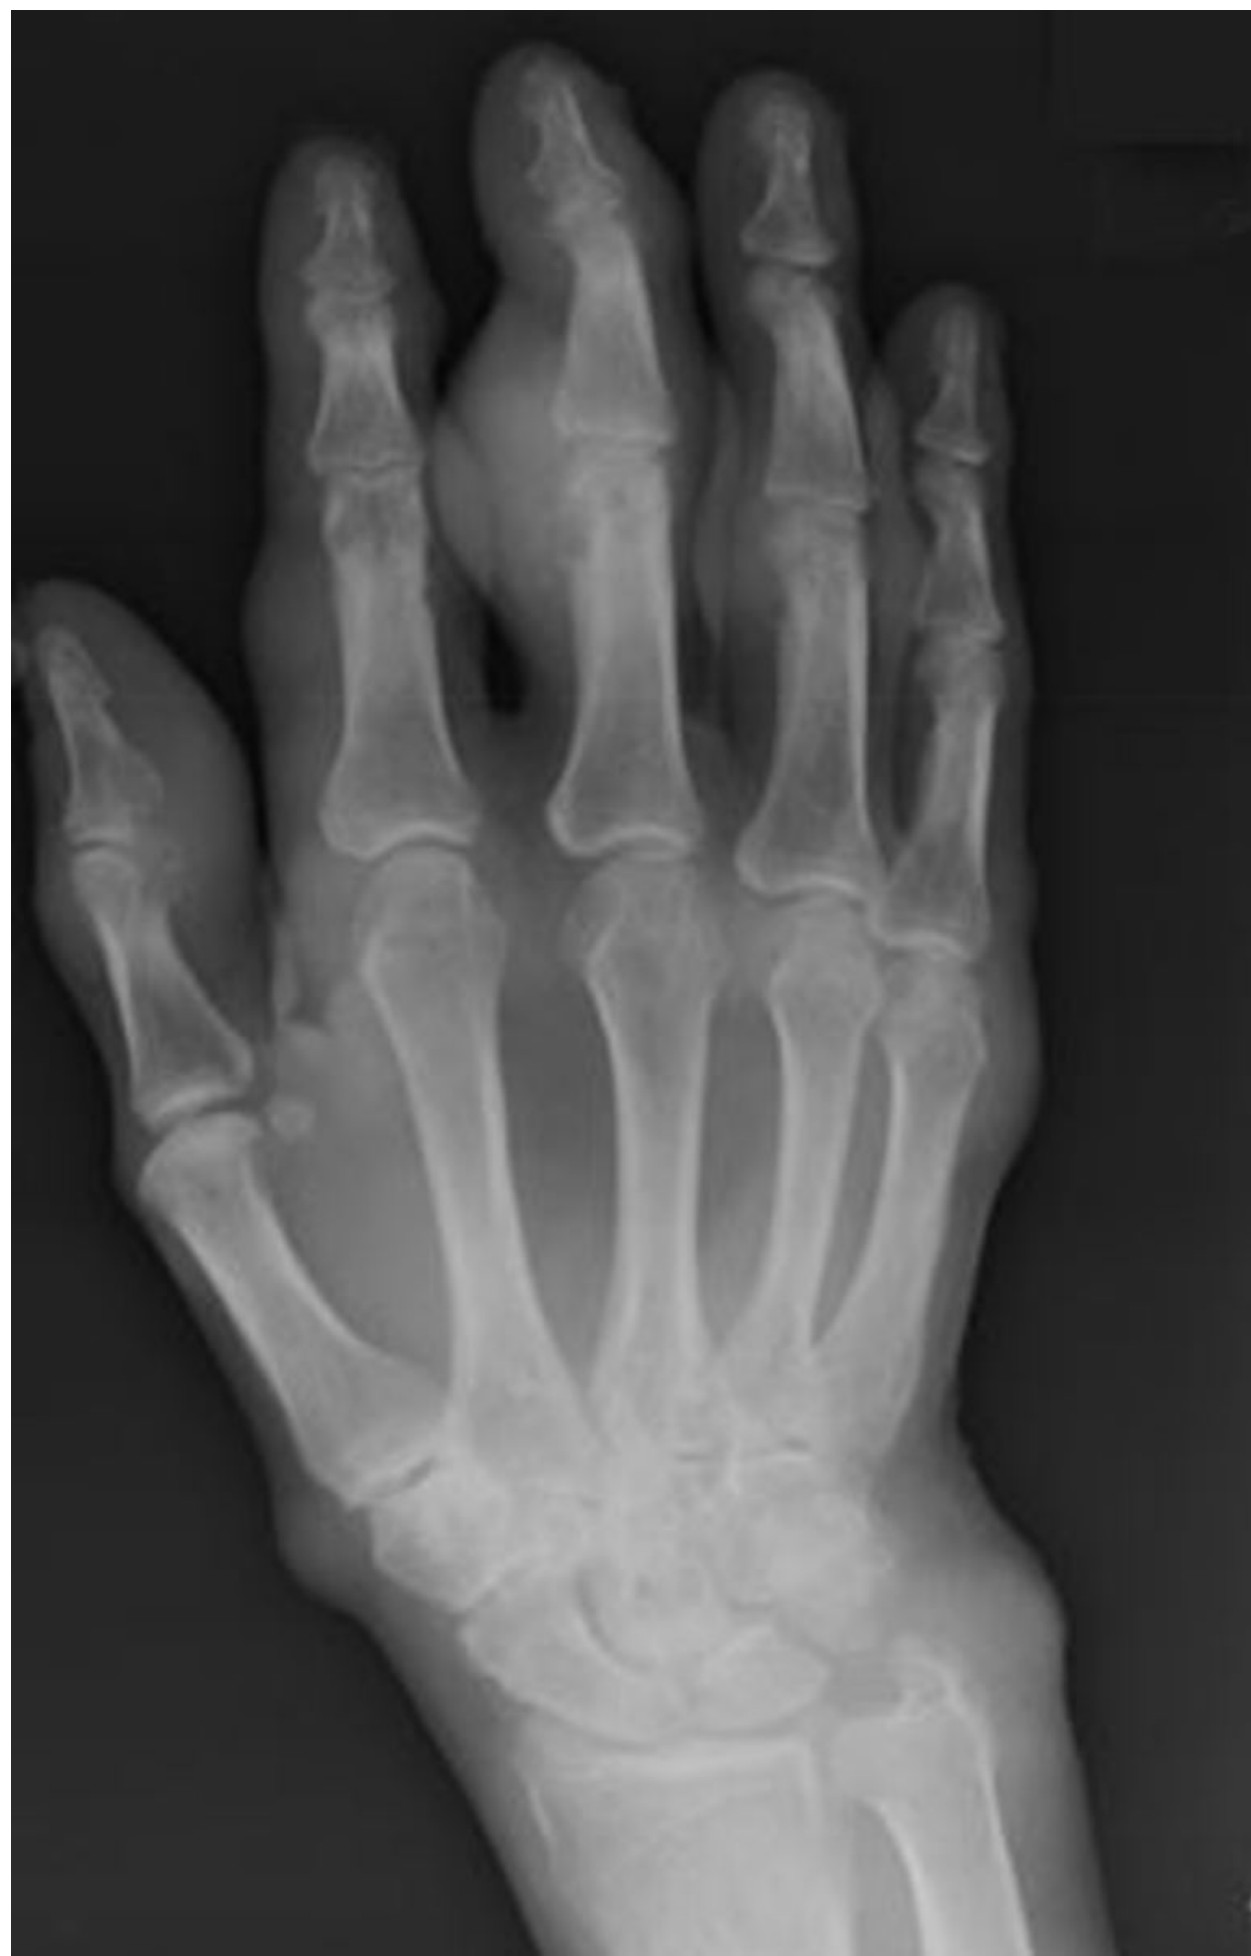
Degenerative joint disease and inflammatory osteoarthritis. PA radiographic view with severe arthritis in PIP joints and slight changes in DIP and MCP joints.
